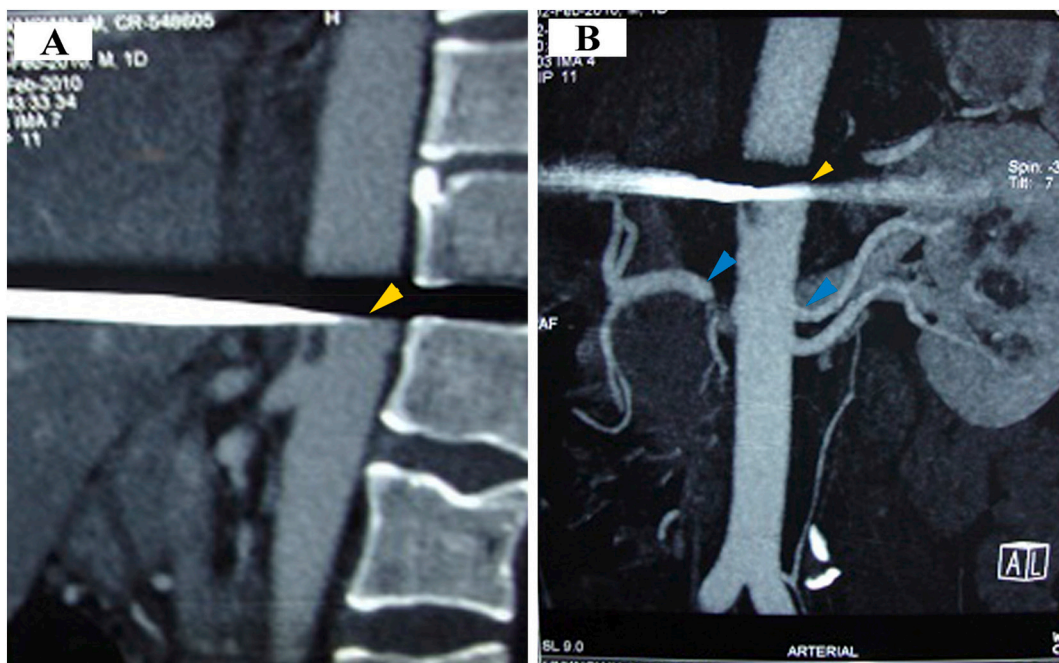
CT Angiography of abdomen.
